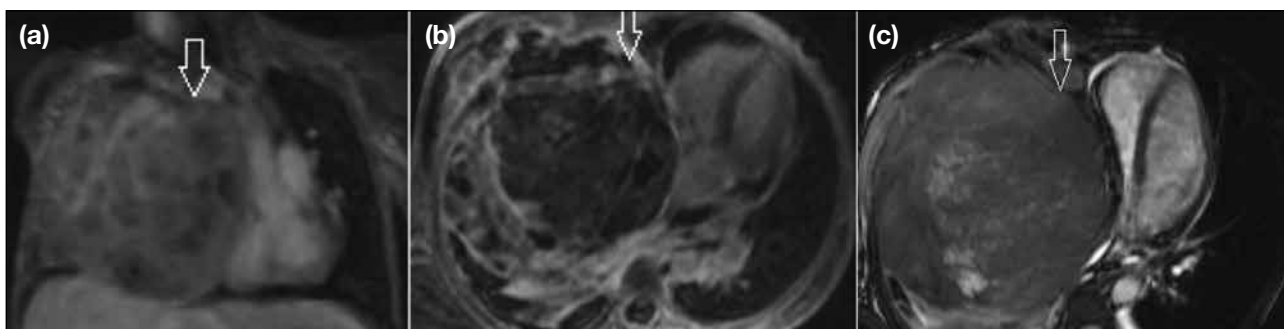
Cardiac magnetic resonance images of a 15-year-old female patient diagnosed with intrathoracic (a) and intraabdominal (b) neuroblastoma (arrows). The tumour has invaded the right atrium (c) [arrow].
